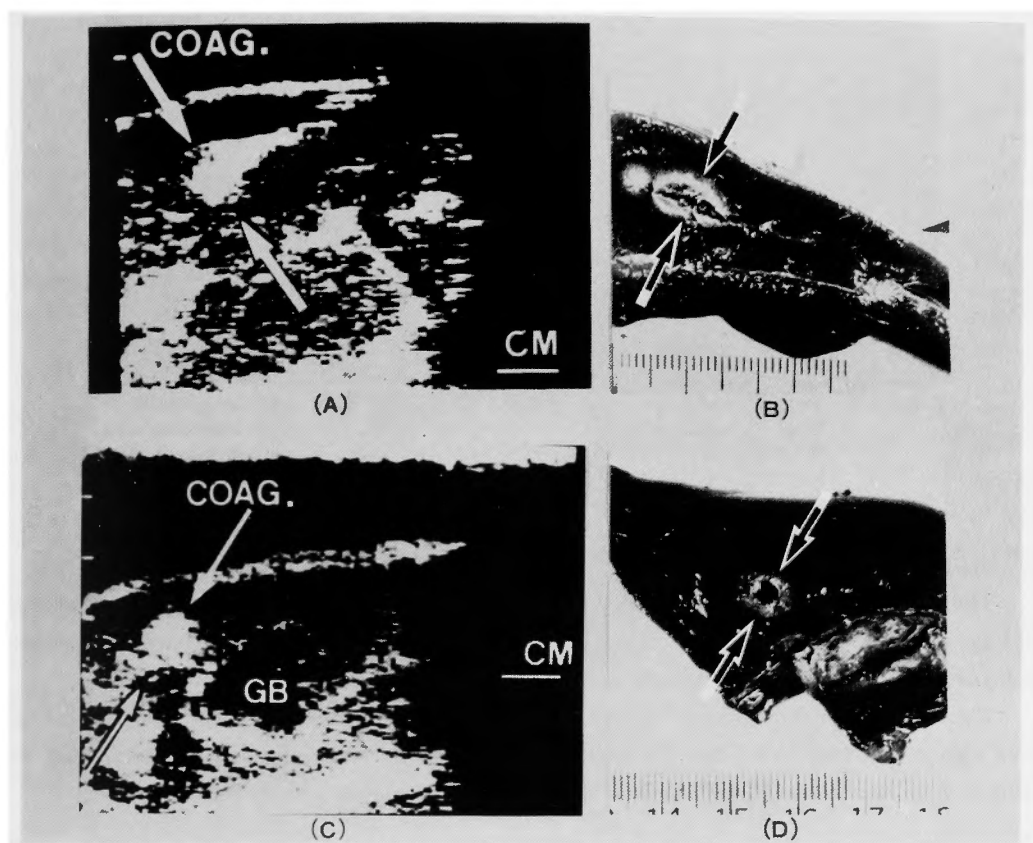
Ultrasonography monitored during and after microwave coagulation (A, C) and view of cut surface of the coagulated area in the removed liver (B, D). A and B: View of the section along the needle-electrode. C and D: View of the section in the direction perpendicular to the needle-electrode. Hyperechoic area (white arrow) is identical macroscopically in shape and range of the coagulated area (black arrow).
